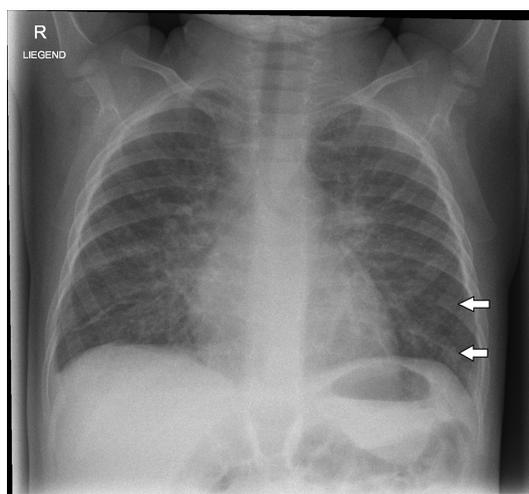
Chest X-ray supine, arrows indicate Kerley B lines.
